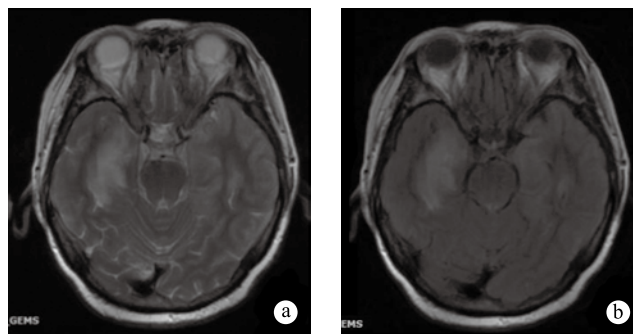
MRI scan: T2WI and FLAIR show slightly higher signal, T1WI shows slightly lower signal
